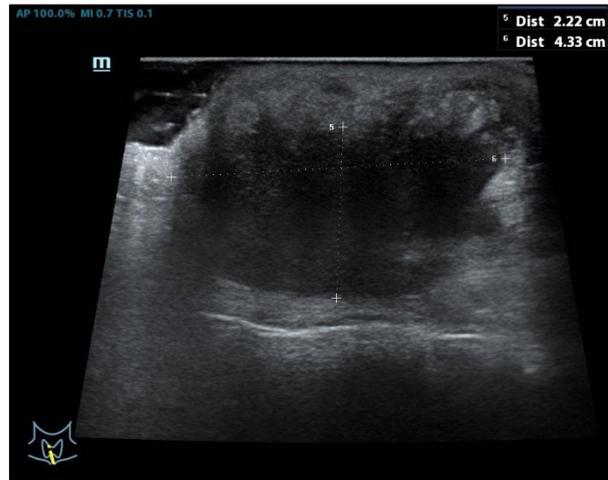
Ultrasound neck shows midline anterior neck collection with moving debris within, arising from thyroid isthmus, measuring 2.2 cm x 2.6 cm x 4.3 cm. The bilateral thyroid lobes were not visualised in keeping with the previous surgery
